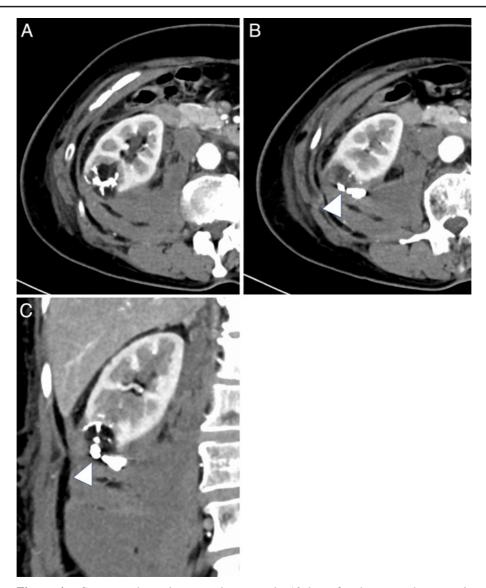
Contrast-enhanced computed tomography 10 days after the transcatheter arterial embolization revealed that the bleeding site was filled with N-butyl cyanoacrylate-lipiodol cast (arrowhead), showing shrinkage of the hematoma.
